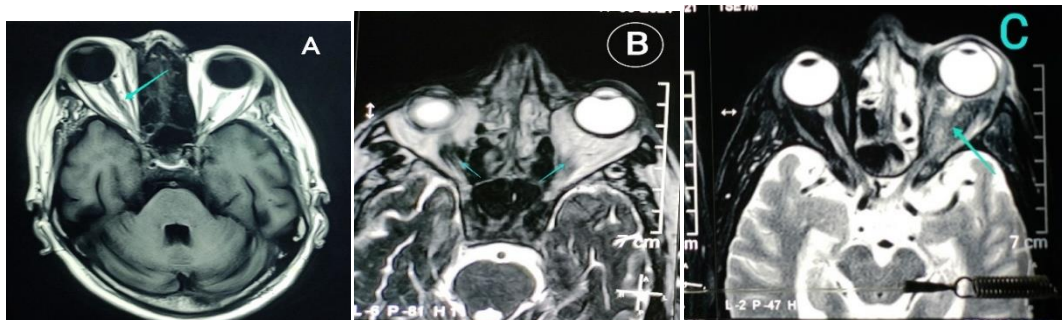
Contrast enhanced T1W MRI showing non-enhancement and thickening of right optic nerve.
